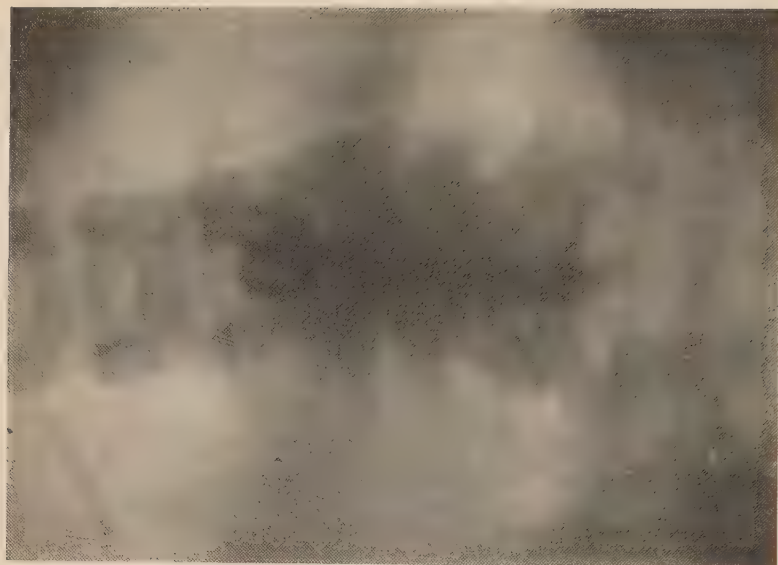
Anteroposterior x-ray taken eighteen months after bone transplantation operation. The graft, as well as the vertebral bodies, has increased in density since the operation.
